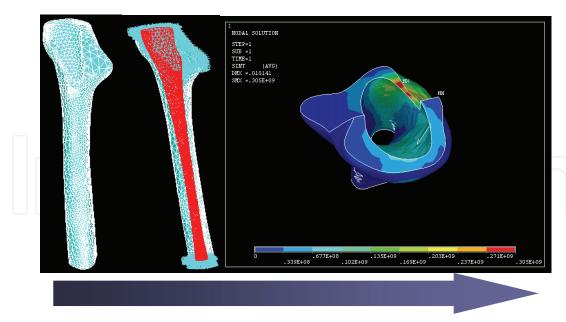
Example of mechanical FEM study based on the information from CT images.
